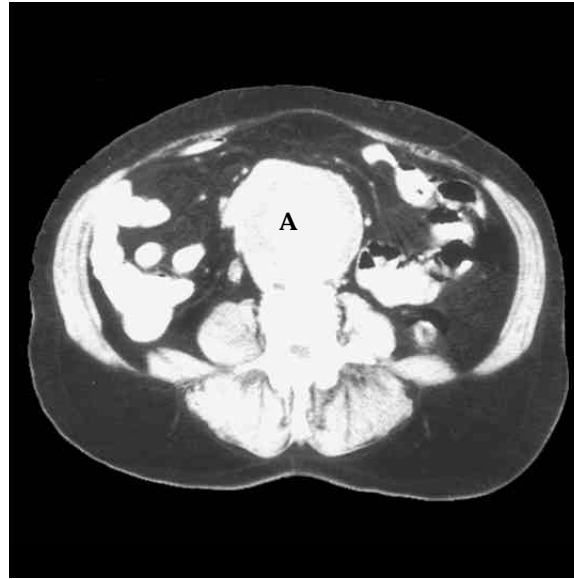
AORTIC ANEURYSM CT image. An aneurysm (A) is a dilation of an artery (SST p. 673). As the artery enlarges, the danger increases that the artery will rupture (SST p. 694). A rupture of the aorta usually results in death. In the brain, a rupture can cause a stroke (SST p. 430).
